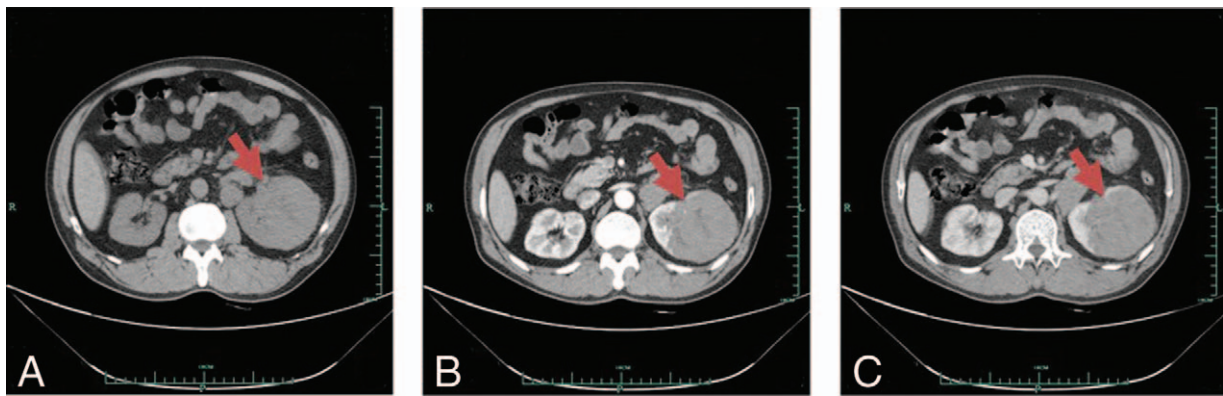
Preoperative contrast-enhanced CT revealed a iso-density occupying shadow in the left kidney measuring about 68×72 mm. After enhancement, it had mild-to-moderate enhancement. (A) Plain scavenging period; (B) enhancement period; (C) substantive period. CT=computed tomography.
